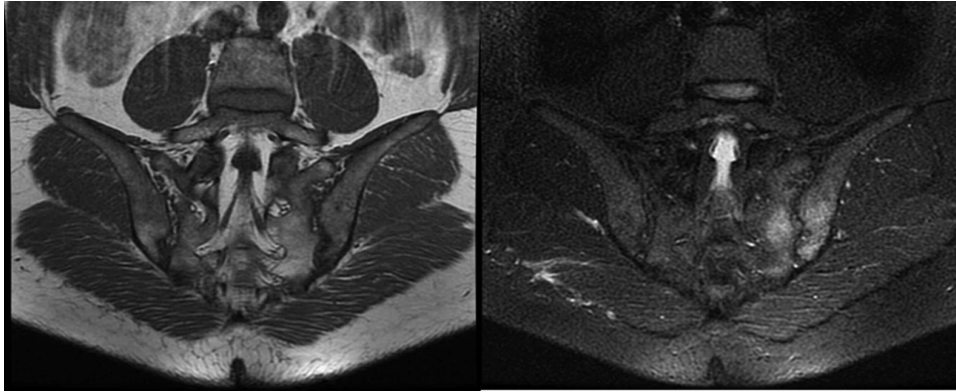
Sacroiliitis on magnetic resonance imaging (MRI) in a patient with acne treated with isotretinoin. Left panel shows SIJ paracoronaral T1-weighted image, and right panel shows STIR MRI. STIR sequences revealed hyperintense lesions compatible with bone marrow edema in both iliac and sacral bones in the left SIJ. SIJ: sacroiliac joint; STIR: short tau-inversion recovery.
